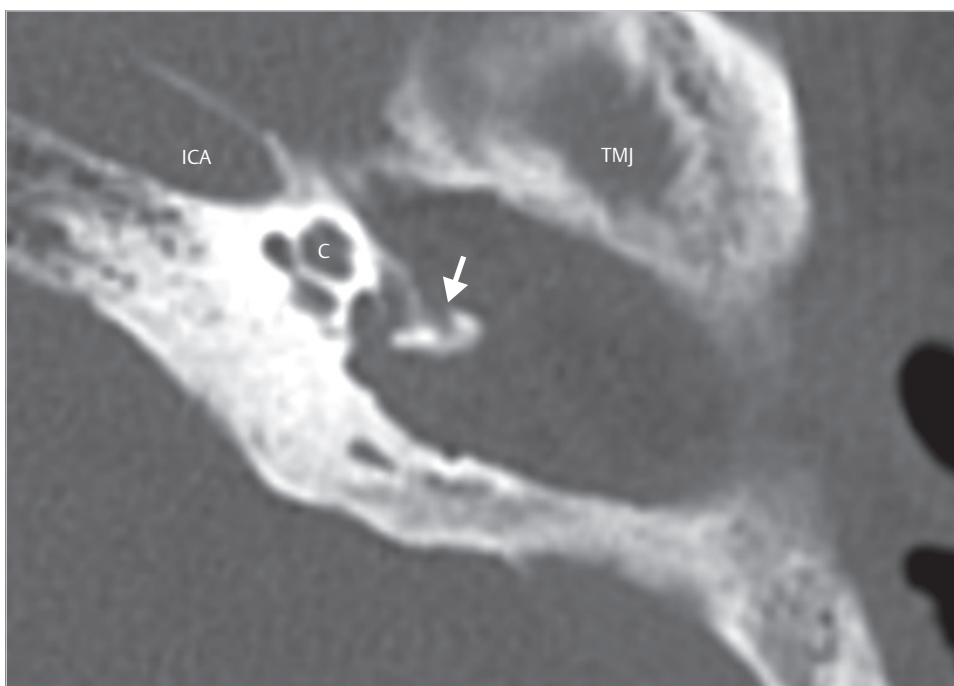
The postoperative CT demonstrates removal of the posterior labyrinth with preservation of the facial nerve (arrow). C, cochlea; ICA, internal carotid artery; TMJ, temporomandibular joint.
